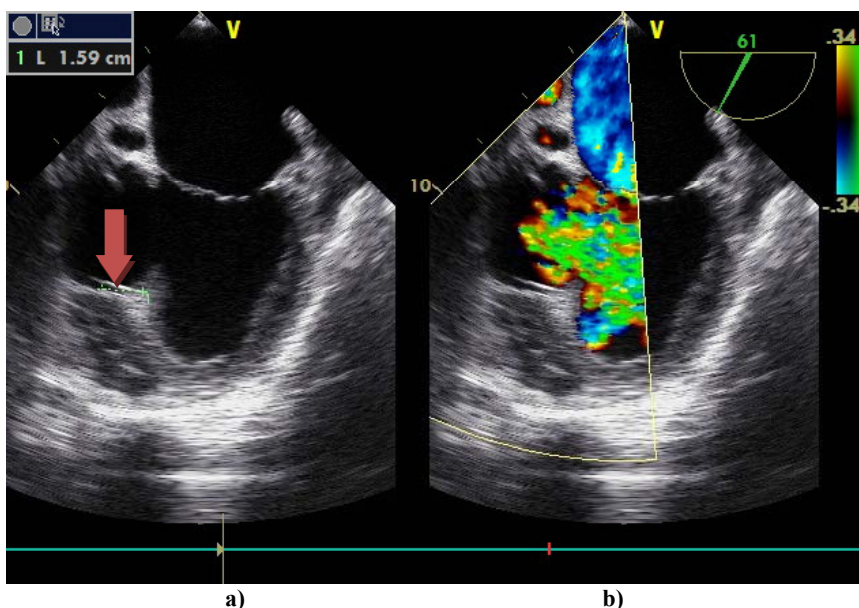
Transesophageal exam (stop frame) without (a) and with color Doppler (b) showing aneurysm of the inferior septum and basal segment of the inferior wall with ventricular septal rupture (arrow).
